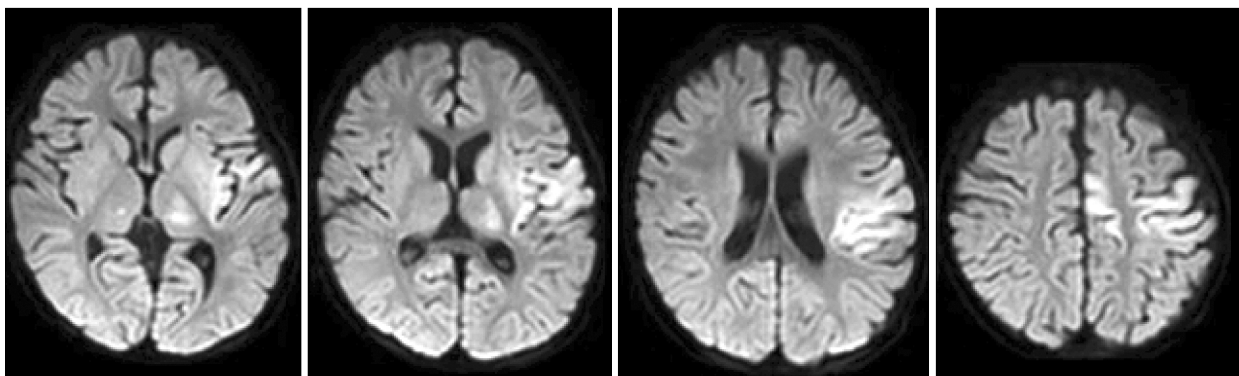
Brain magnetic resonance imaging (MRI). MRI showed multifocal diffusion restriction area in left insula, deep gray matter and bilateral peri-rolandic area.
